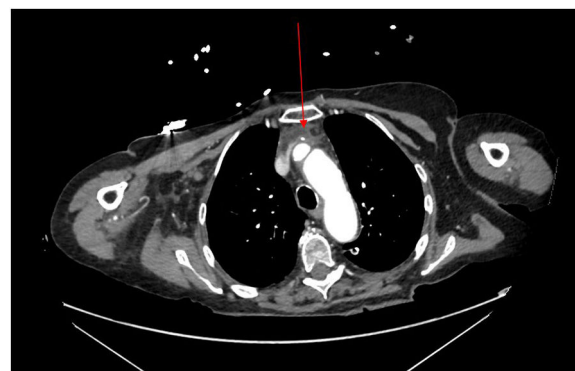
CT scan imaging showing the central venous catheter impacting the innominate vein.
